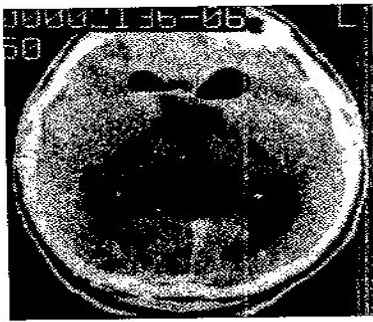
Case 6. Postoperative CT scan revealing a very thin fragment of capsula as a small remnant of the surgically treated lesion.
